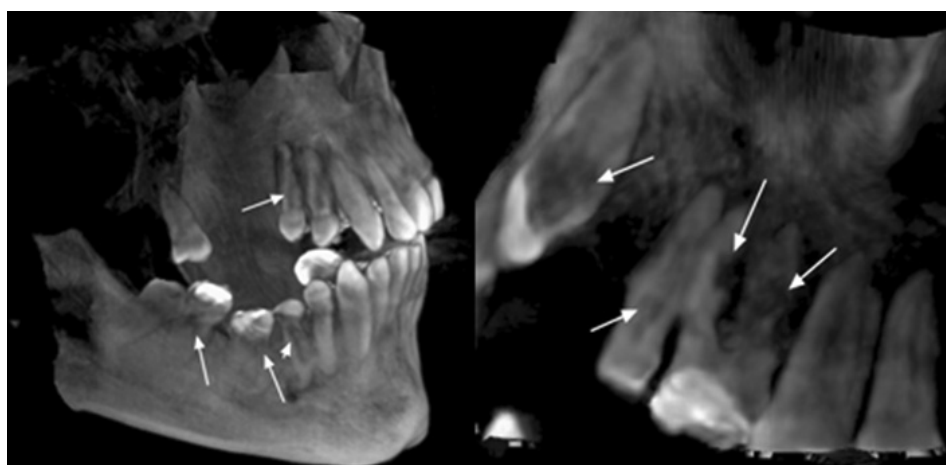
Three-dimensional cone-beam computed tomographic volume rendering images clearly show external and internal resorption (arrows).
